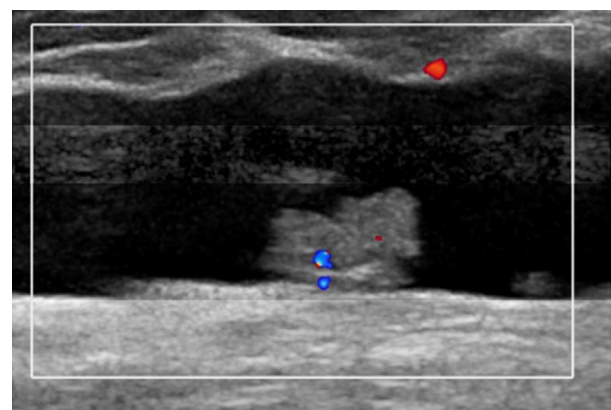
Ultrasound image demonstrating mural nodule with vascularity. Image courtesy of BreastScreen ACT.
